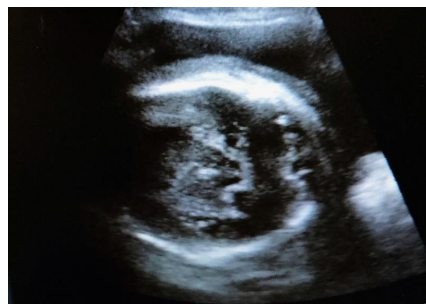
Ultrasound image of left occipito-transverse position.
